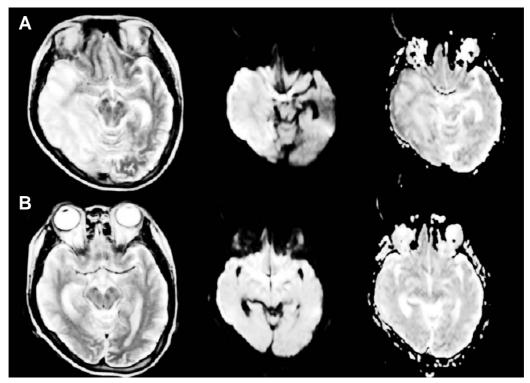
A and B Brain MRI (T2 weighted image, diffusion weighted image, ADC map, in order of figure). (A) Axial T2-weighted and diffusion weighted images show high signal intensity in right temporo-occipital and left temporal cortices and delayed normal signal intensity on ADC map in same lesion. (B) Follow-up images obtained 2 months later show resolution of the lesions.
